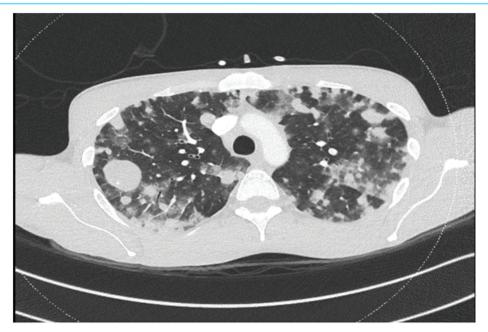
Chest CT-scan showing large alveolar infiltrates of both fields and enlarging pre-existing lymphadenopathies.
